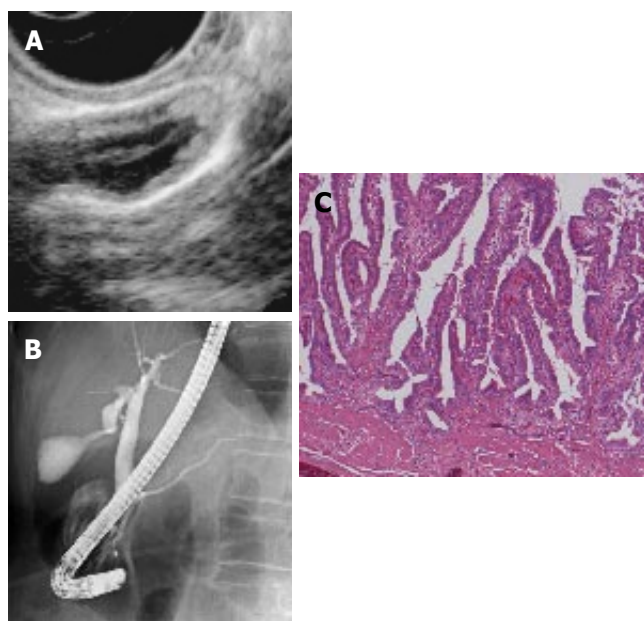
The 52-year old woman who had extremely high biliary amylase level without pancreaticobiliary maljunction and gallbladder carcinoma limited within the mucosa. A: Ultrasonography, showing diffuse thickness of the gallbladder wall above 3 mm; B: ERCP shows no pancreaticobiliary maljunction and common channel of 7 mm. Biliary amylase levels in the common bile duct was 52 600 IU/L; C: Gallbladder carcinoma limited within the mucosa (HE, x 40).
